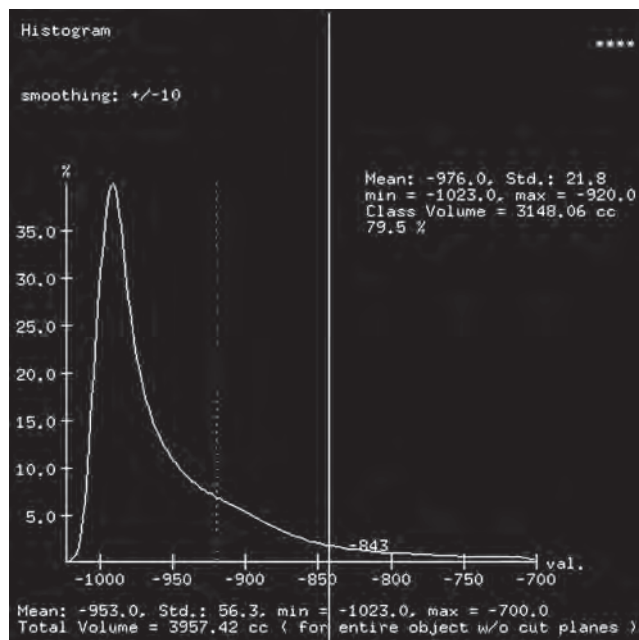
The appearance and frequency of a range of CT numbers within a region of interest are displayed on a histogram.
